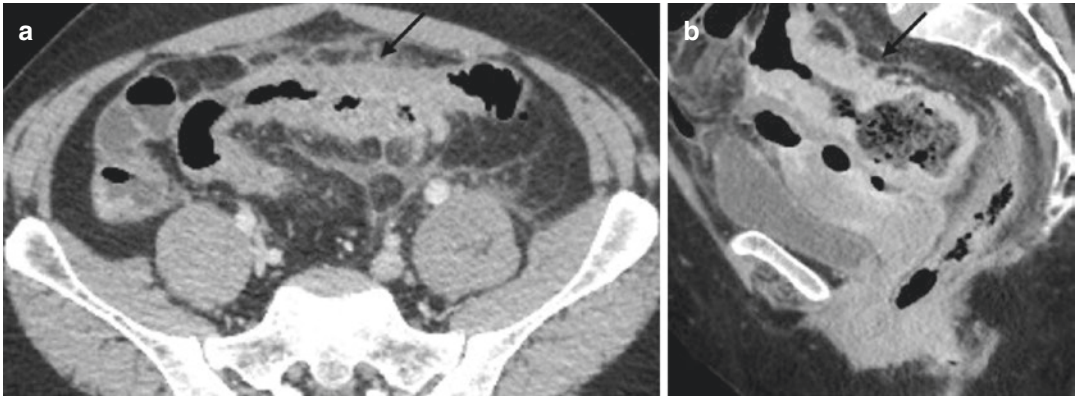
CT in axial (a) and in sagittal views (b) of two different elderly patients presenting with acute pelvic pain, in the first case (a) related to acute diverticulitis (a, arrow) and in the second one (b) related to sigmoid cancer (b, arrow). Note the morphological differences between the different bowel wall thickenings and the fat stranding due to the peridiverticular inflammatory reaction (a), absent in the second case (b)
